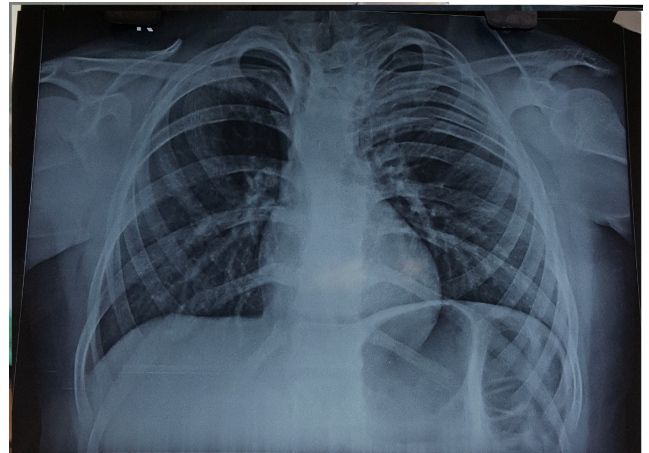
Chest X-ray (PA) revealed unequal number of ribs (7 on right & 11 ribs on left side), left upper ribs crowding, elevation of left hemidiaphragm, hyperlucency in right upper zone, upper thoracic scoliosis and a normal cardiac silhouette
